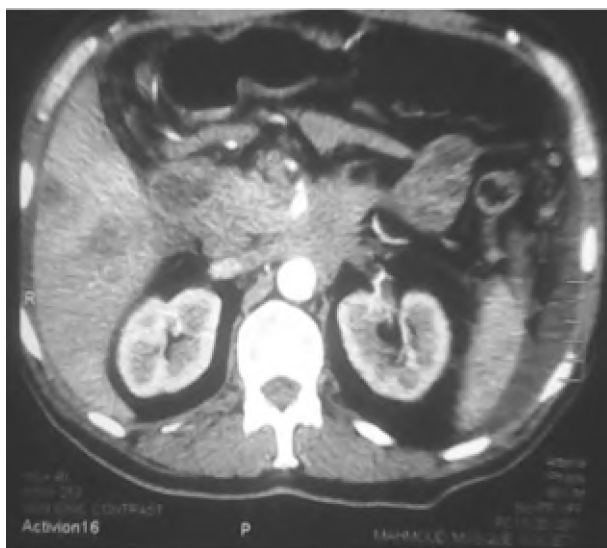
Multislice CT axial image arterial phase showed superior mesenteric artery encasement and hepatic focal lesions are detected as well as perihepatic and perisplenic fluid collection.
